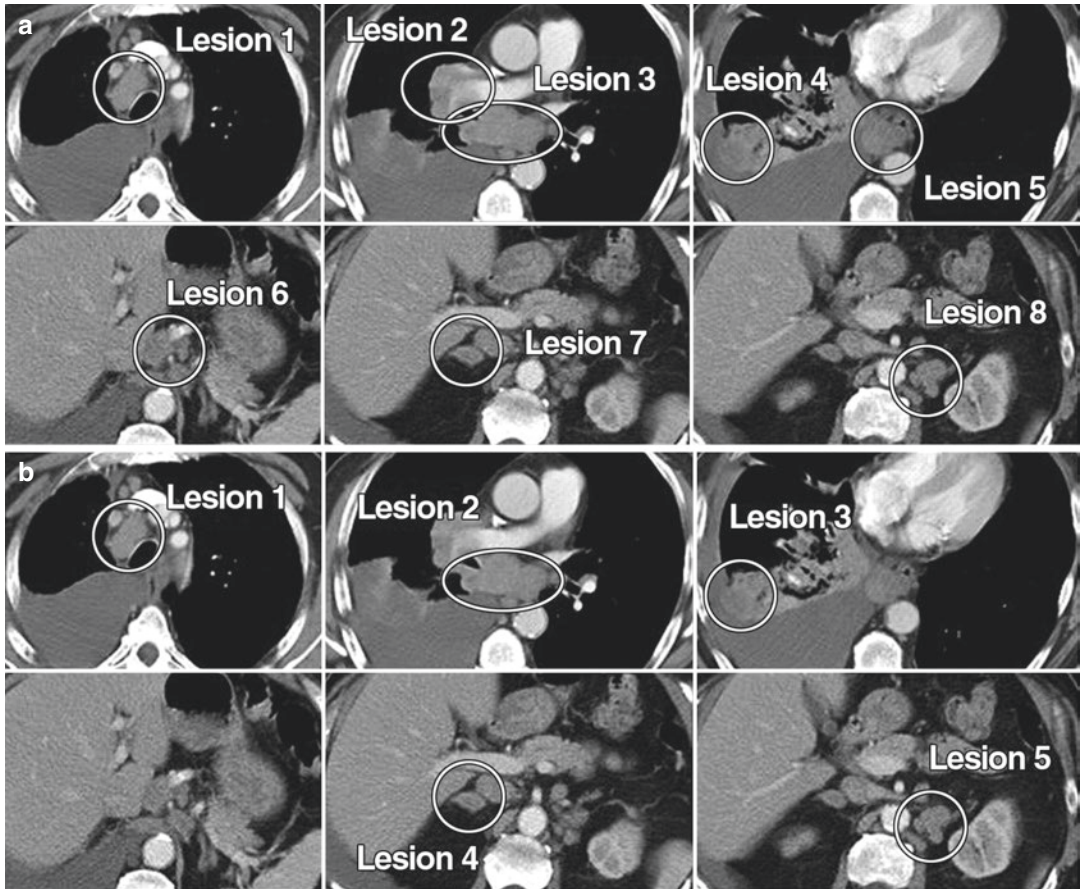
Number of target lesions according to RECIST 1.1 has been reduced to up to five total. CT scans of chest in 74-year-old man with advanced NSCLC show multiple enlarged thoracic and upper abdominal lymph nodes, lesion in right lower lobe of lung, and bilateral adrenal metastases. (a) Using RECIST 1.0, which allows up to 10
